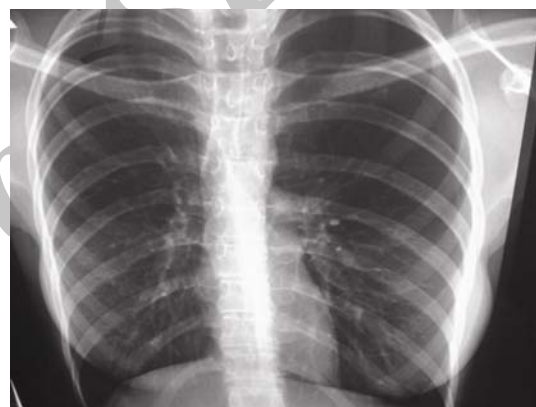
Chest X-ray after one-year showed no visible residual cysts.
